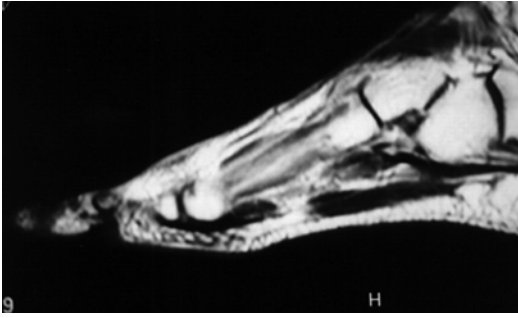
Bone edema and periosteal reaction due to metatarsal stress fracture, as seen on MRI
